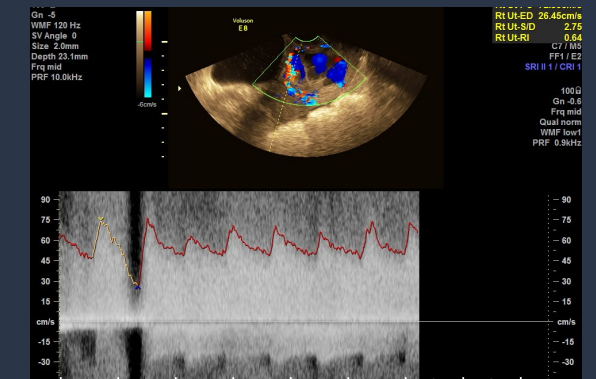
transvaginal colour and pulsed Doppler ultrasound of the abnormal vasculature.
